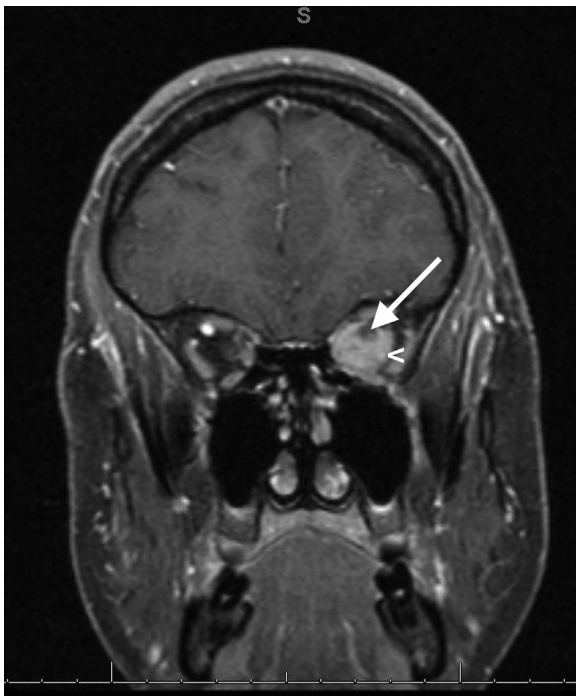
Coronal T1 fat-saturated postcontrast magnetic resonance imaging (MRI) through the midorbits demonstrating homogeneous enhancement of the mass (arrow head) encasing the left optic nerve (arrow).
